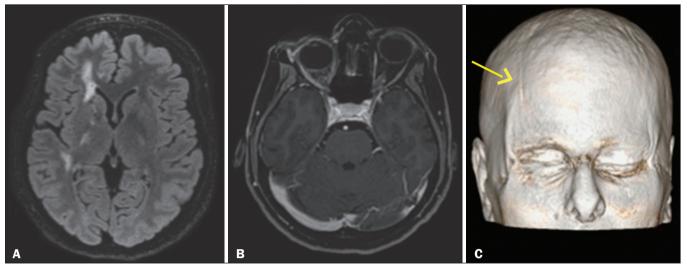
Female patient being followed for convulsions. A: Axial MRI FLAIR sequence of the skull showing areas of signal hyperintensity in the subcortical white matter and the internal capsule on the right. B: Contrast-enhanced T1-weighted sequence showing facial asymmetry, best demonstrated in three-dimensional reconstruction (arrow in C).
